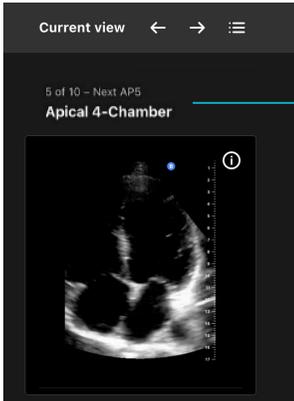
Basic ultrasound display and controls
